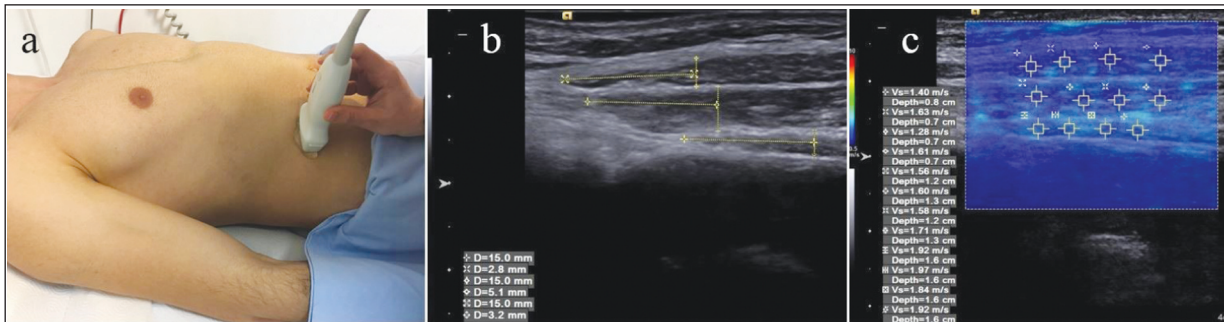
(a,b,c) Probe location and ultrasound imaging measurements.
